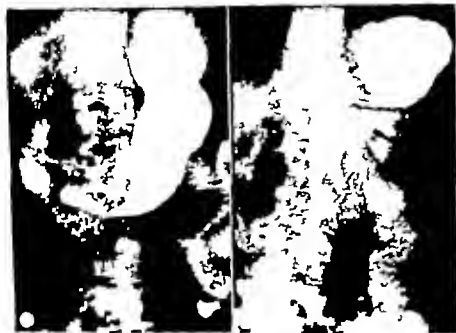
a. Preoperative appearance of the stomach of woman 54 years old with an adenocarcinoma of the stomach who underwent operation on Oct. 16, 1945. b. Stomach of the same patient as involved on Feb. 25, 1946. There is no roentgenologic evidence of recurrence.
